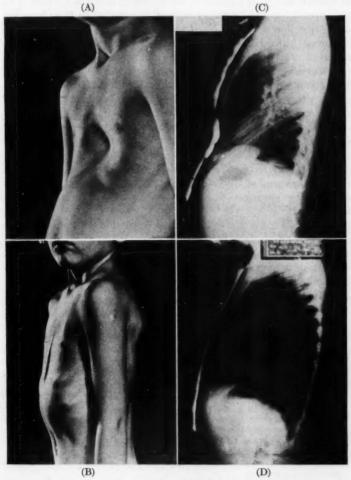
A. Condition before operation. B. Condition three weeks after operation. C. Preoperative lateral roentgenogram. D. Postoperative lateral roentgenogram. (Reported in Ravitch, M. M., Ann. Surg., Vol. 129, April 1949).
